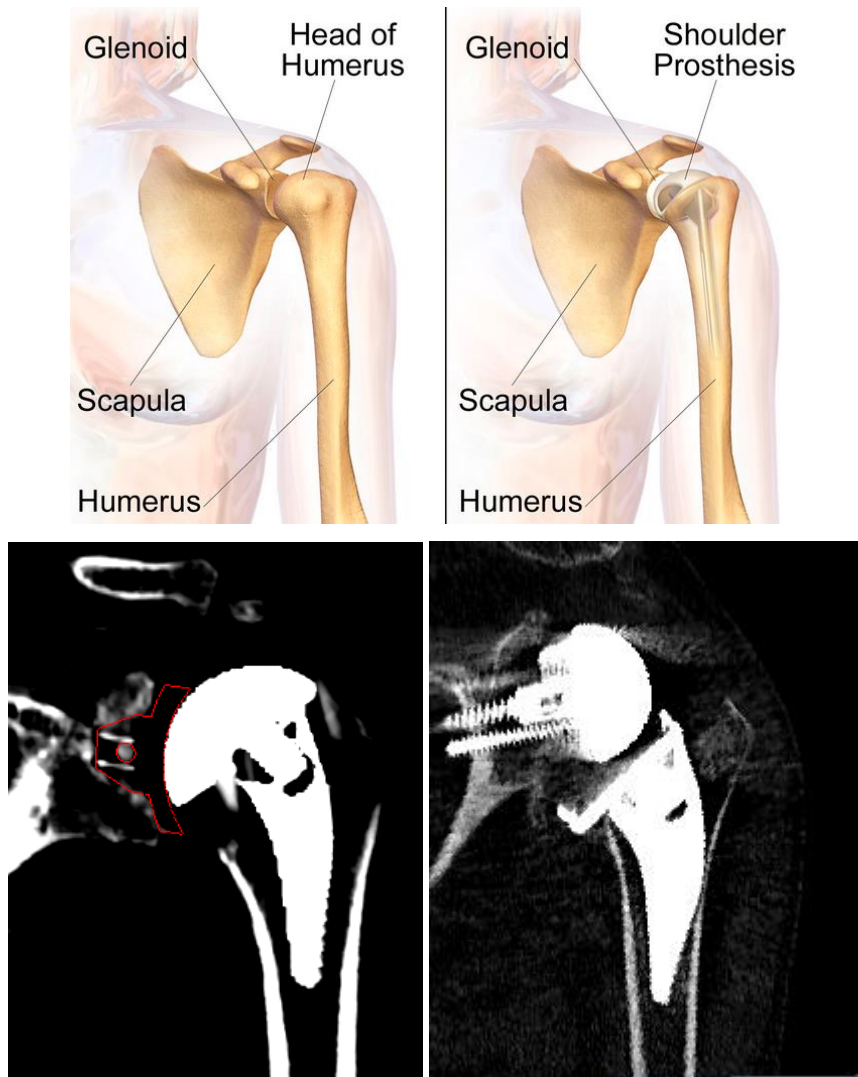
4 Top: Depiction of Total Shoulder Arthroplasty. Bottom: Postoperative computed tomography images of anatomical Total Shoulder Arthroplasty (aTSA, left) versus reverse Total Shoulder Arthroplasty (rTSA, right).
